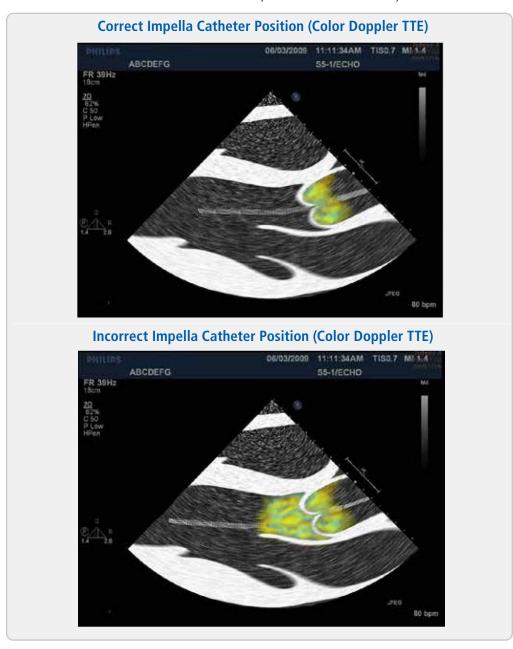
Correct and Incorrect Impella Catheter Position (Color Doppler TTE)
